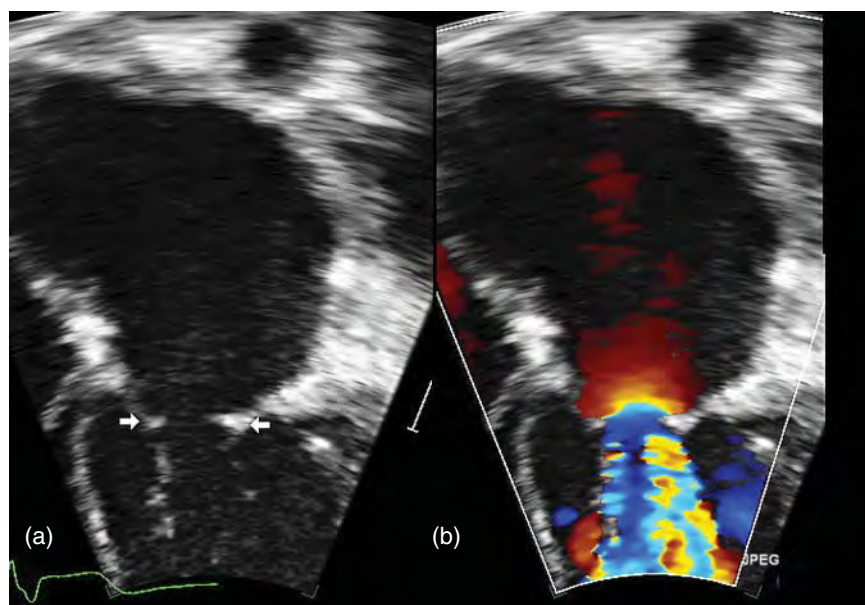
(a) Supramitral ring (white arrows) along the atrial surface of the mitral leaflet. LAA, left atrial appendage; MV, mitral valve. (b) Color Doppler demonstrating aliased flow velocity during diastole consistent with stenosis.
